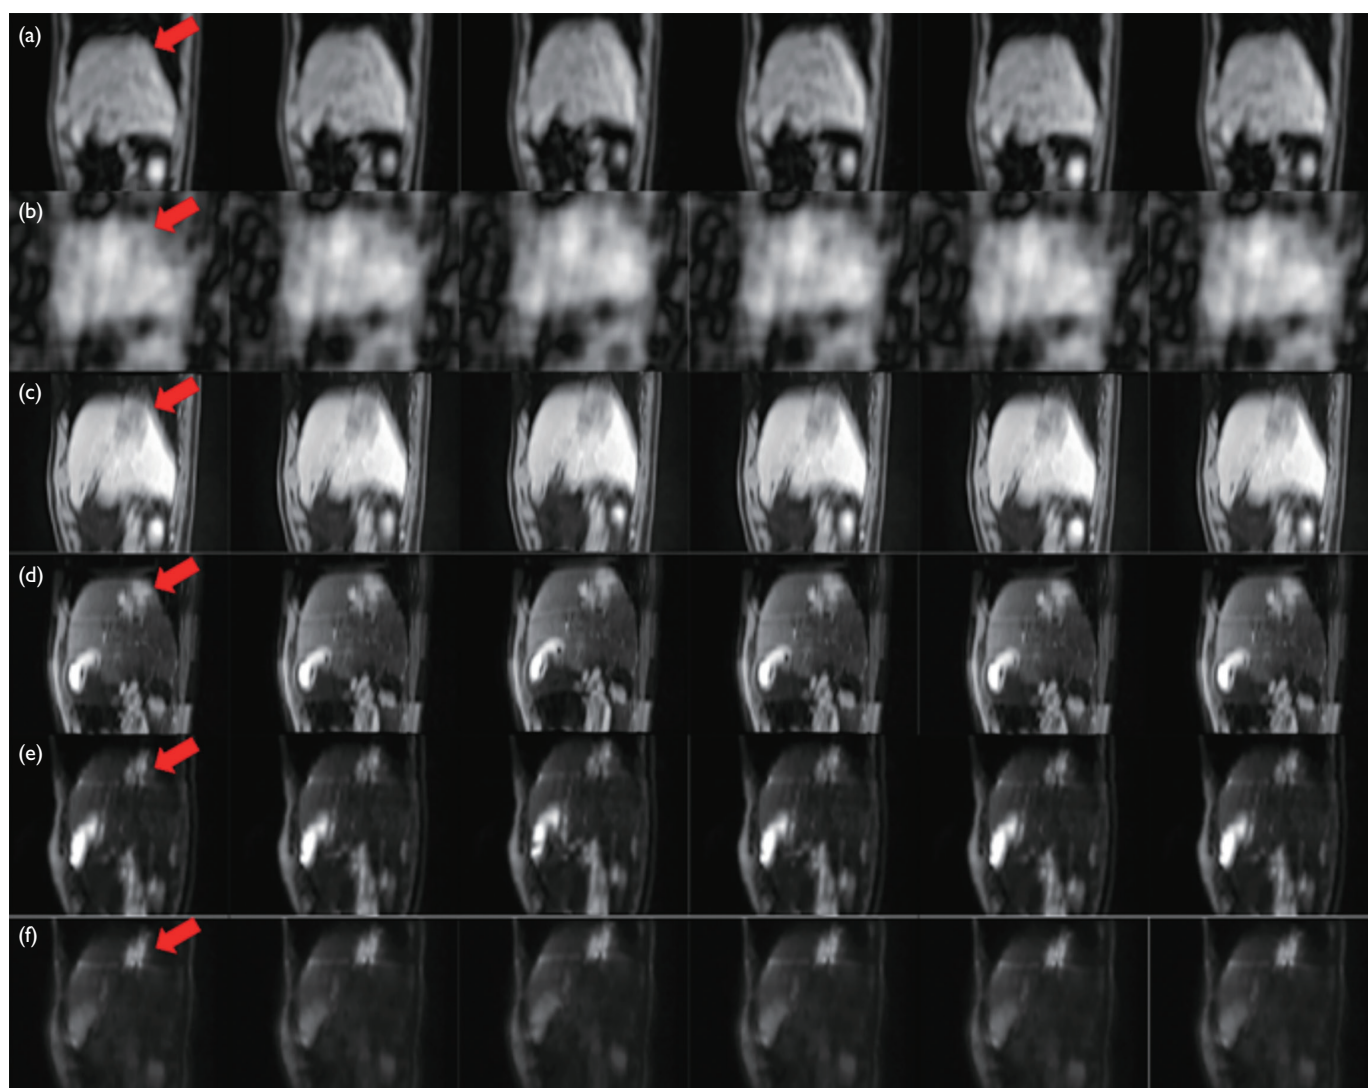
Reconstructed images in the sagittal view from a sample patient: (a) original four-dimensional (4D) magnetic resonance imaging (MRI), (b) downsampled 4D-MRI, (c) T1-weighted 4D-MRI, (d) T2-weighted 4D-MRI, (e) 4D-diffusion-weighted imaging (DWI) [b=50], and (f) 4D-DWI (b=800)
